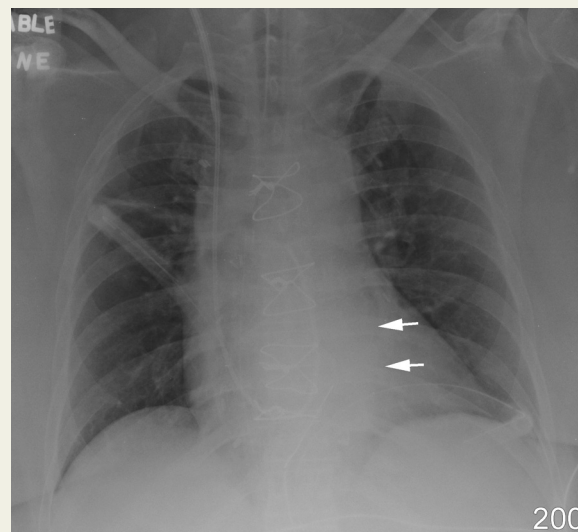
Post-operative chest radiograph in a 63-year-old woman depicts grade 1 atelectasis in the left lower lung zone (arrows).
